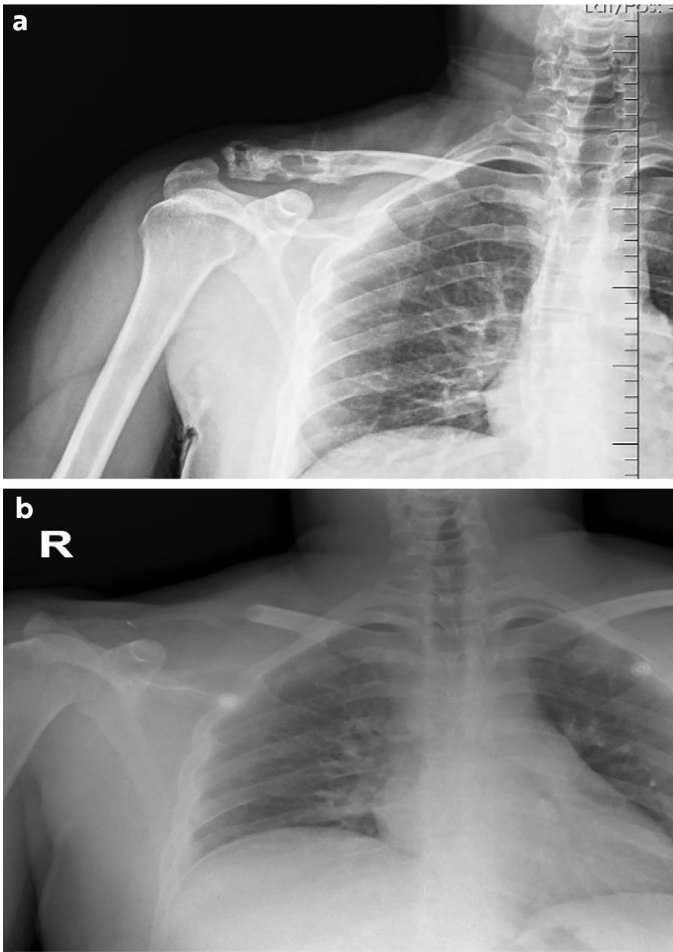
(a) Preoperative roentgenogram of 39 year old male patient with clavicle-originated Ewing sarcoma. (b) Postoperative roentgenogram shows wide resection of the clavicle performed
